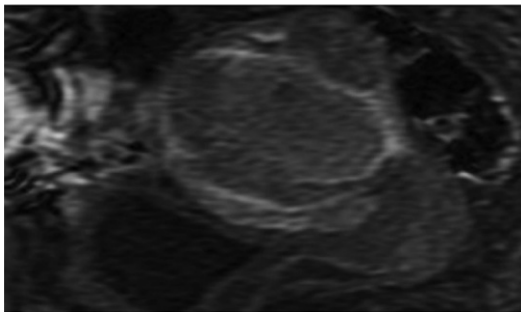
Endometrial carcinoma with outer half myometrium invasion. DCE-MR imaging. Three-dimensional T1-weighted fast-spoiled gradient-recalled sagittal section.
